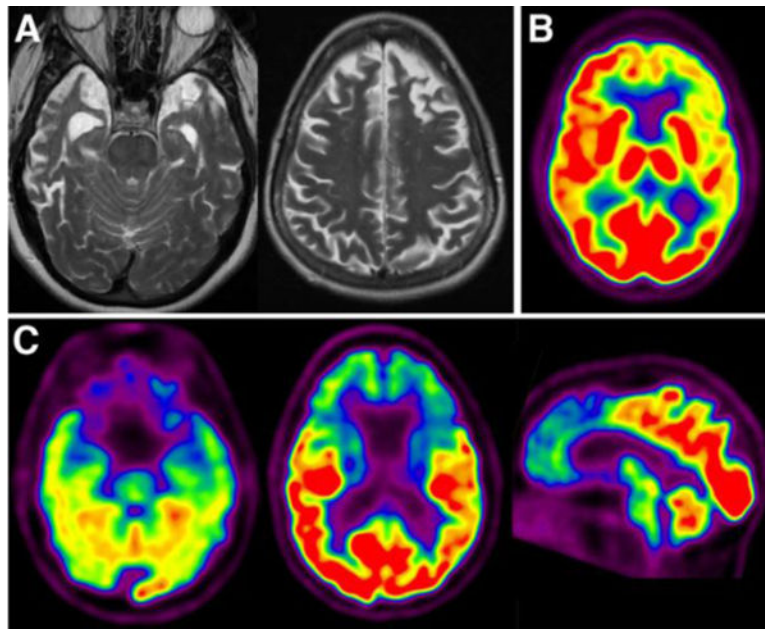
Neuroimaging in FTLD. (A) Axial T2 images from two patients show two characteristic patterns of FTLD: anterior temporal and frontal atrophy. Both show asymmetry and knife blade appearance of the gyri. ^{18}F -FDG PET shows two typical patterns: left frontotemporoparietal hypometabolism (B, axial) versus frontal-predominant (C, axial and sagittal).
